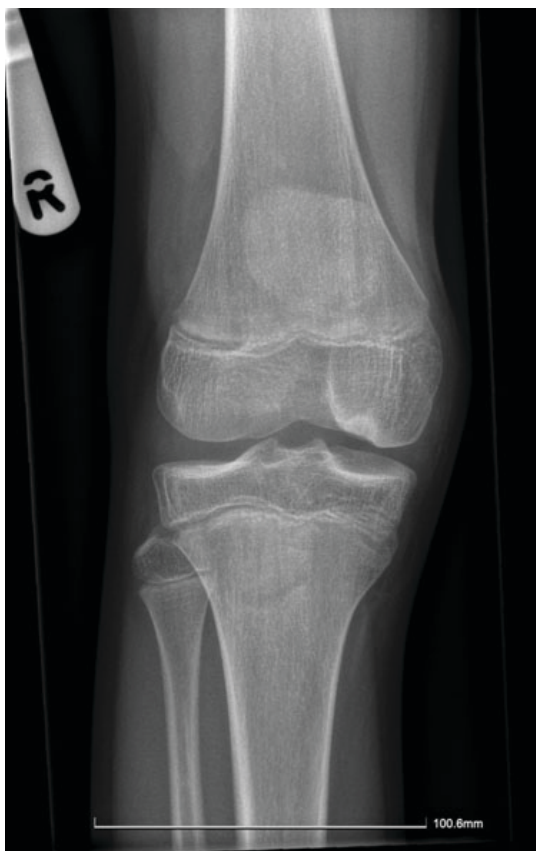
Plain radiograph of the right knee, revealing the medial femoral condyle OCD.
